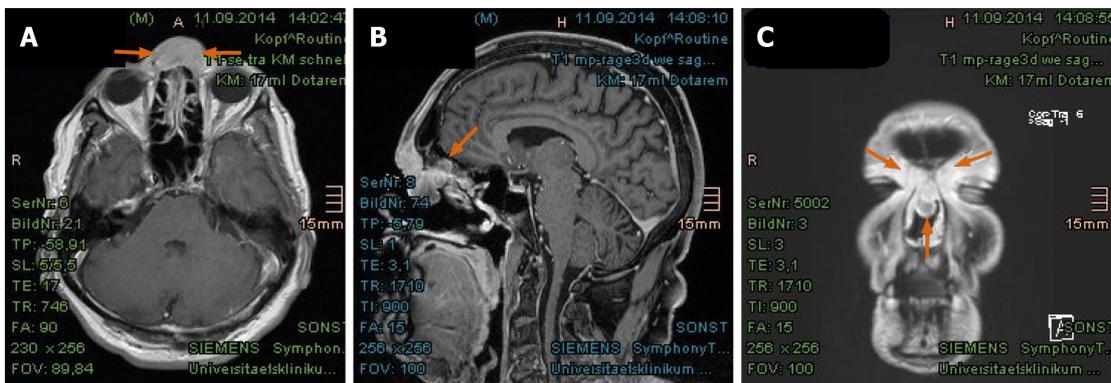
Magnetic resonance imaging from September 2014 revealed tumorous enhancement in the nasal bridge abutting frontal sinus and skull base. A: Axial plane; B: Sagittal plane; C: Coronal plane. Local recurrence marked with arrows.
